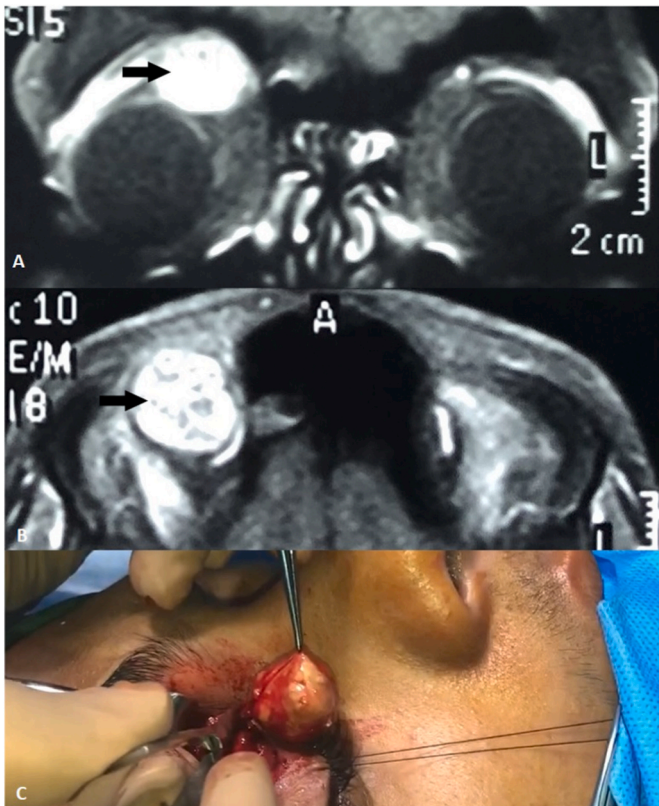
29-year-old male with a dermoid cyst on levator palpebral muscle (Case NO.6). A and B: Coronal and Axial T1 weighted magnetic resonance imaging (MRI) shows a well-defined mass in the supra nasal area of the right eye. C: Intraoperative image of complete removal of the dermoid cyst via anterior orbitotomy.
